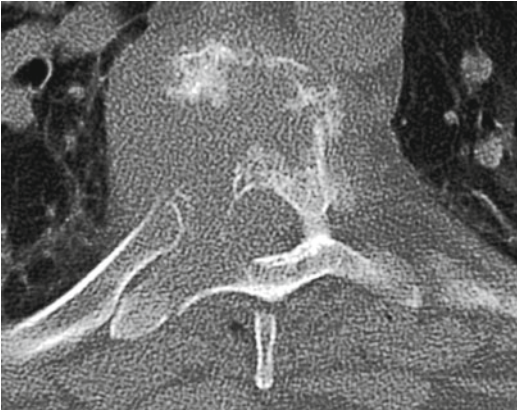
Axial CT reconstruction demonstrating soft tissue infiltration of the vertebral body and pedicle
